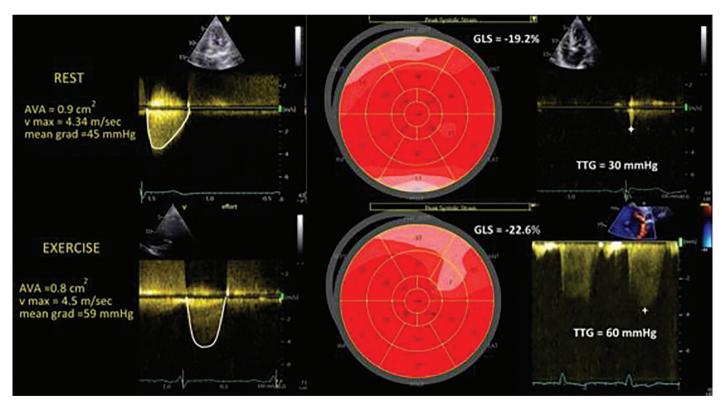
Exercise stress echocardiography in an asymptomatic patient with severe aortic stenosis (AS). Rest echocardiographic evaluation (upper panel) confirms the presence of high-gradient severe AS with preserved left ventricular ejection fraction (rest EF estimated at 60%, not shown), preserved LV-GLS, and transtricuspid pressure gradient (TTG) at rest measured at 30 mm Hg. The patient stopped the test prematurely (maximum heart rate, 99 bpm, representing 65% of the maximum predicted heart rate) because of severe dyspnea, which persisted for a long time in the recovery period. There was neither a decrease in systolic blood pressure nor other symptoms. At exercise echocardiography (lower panel), the mean aortic pressure gradient increase was 14 mm Hg, EF reached 67%, and LV-GLS was 22.6%, indicating the presence of contractile reserve. At exercise, the TTG also markedly increase but at an early stage indicated significant pulmonary hypertension. The case of the patient was discussed in the heart team meeting, and surgical aortic valve replacement was scheduled
